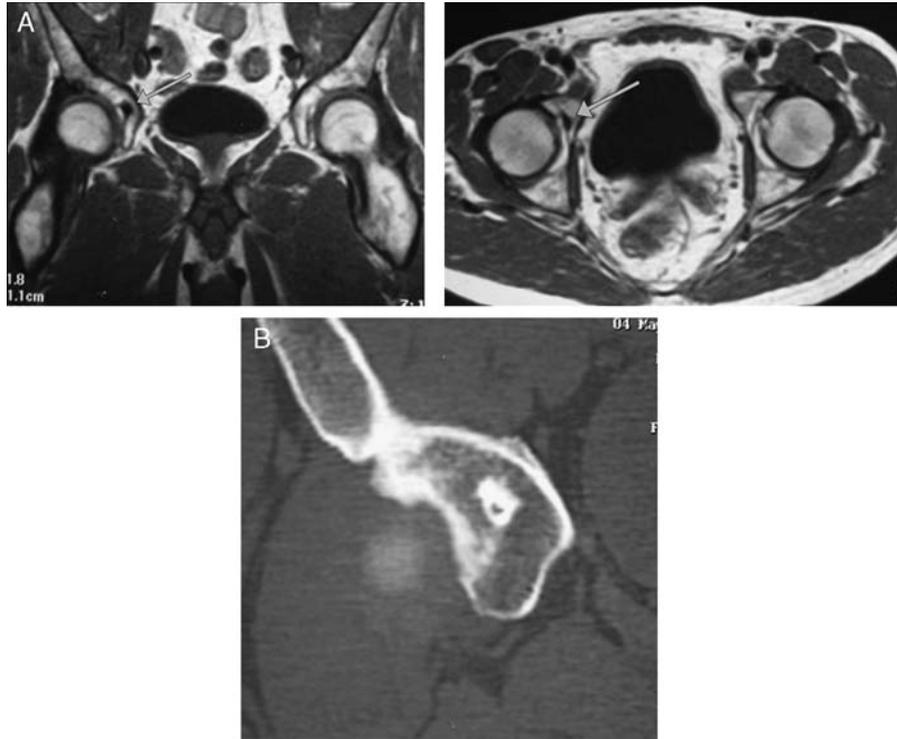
Patient 2. Tomography (A) and MRI (B) images confirmed the suspicions of the osteoid osteoma in the right acetabulum.
